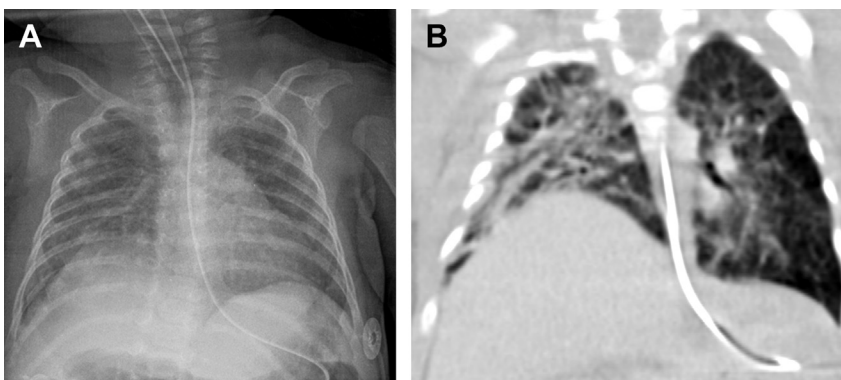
A 3-month-old girl born premature at 26 weeks gestation with chronic lung disease of prematurity. (A) Chest radiograph shows bilateral coarse interstitial opacities, atelectasis, and right hemidiaphragm elevation due to right lung volume loss. (B) Coronal lung window CT image demonstrates bilateral ground glass opacities, septal thickening, and atelectasis that are greater on the right with right hemidiaphragm elevation.
